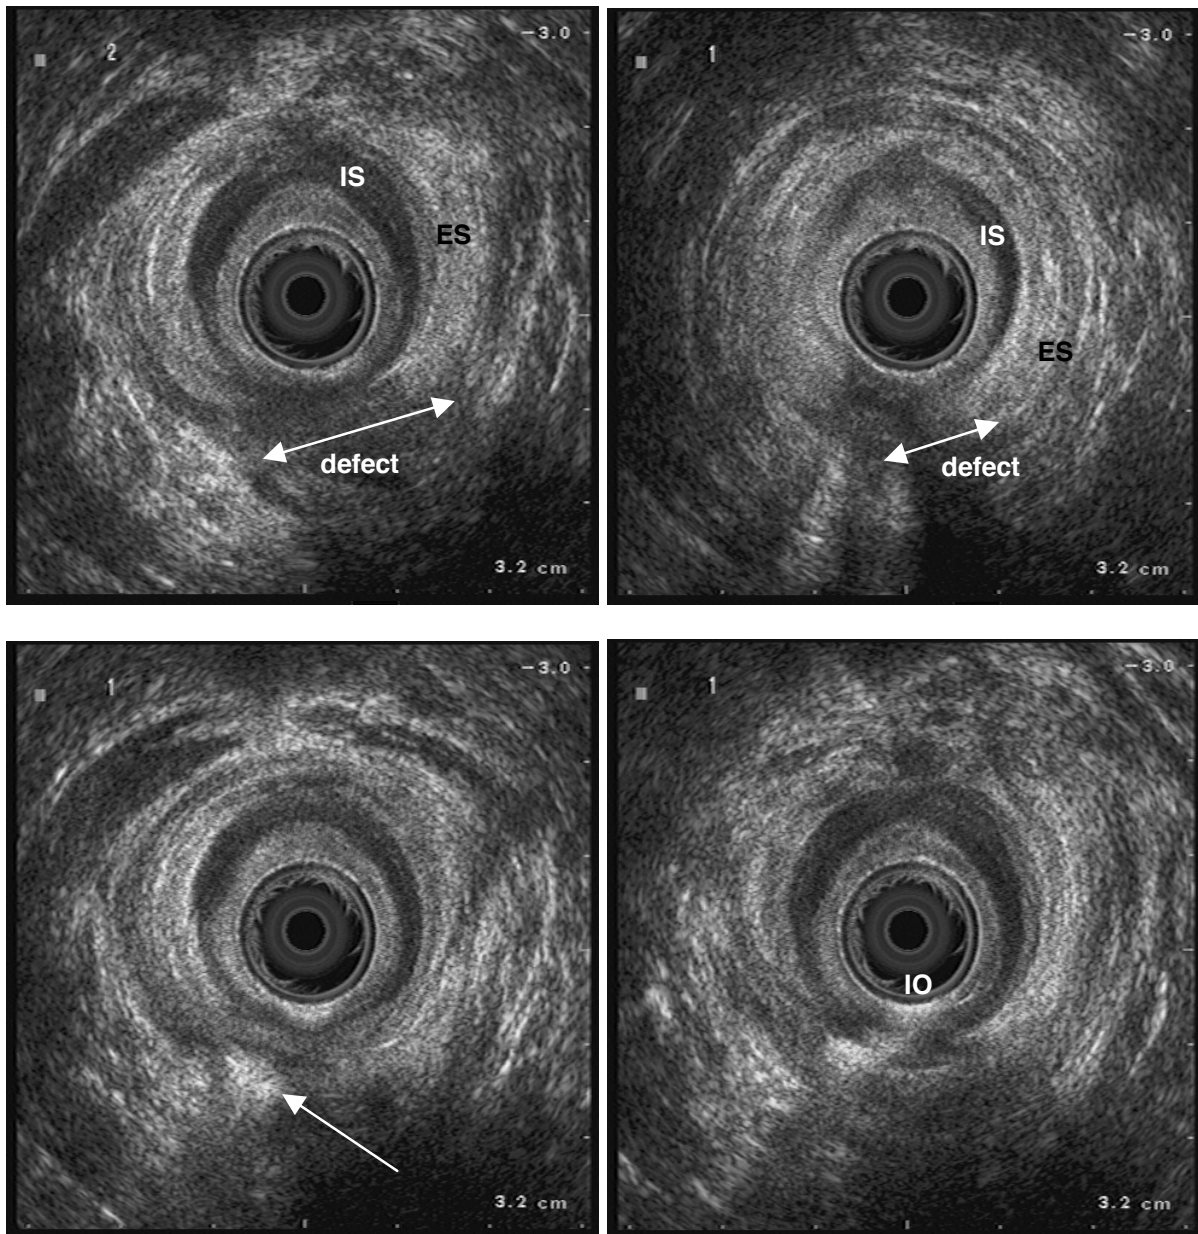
Transanal ultrasound showing a recurrent transsphincteric fistula. 1A (Top Left) Endosonography without hydrogen peroxide shows a defect as a dark area clockwise from 5 until 7 hours posteriorly in external anal sphincter (ES) and internal anal sphincter (IS) and 1B (Top Right) more caudally . 1C (Down left) After injection of hydrogen peroxide via the external opening the fistula-in-ano becomes visible (arrow) as a bright hyperechoic lesion and 1D (Down right) the internal opening (IO) can be detected.
